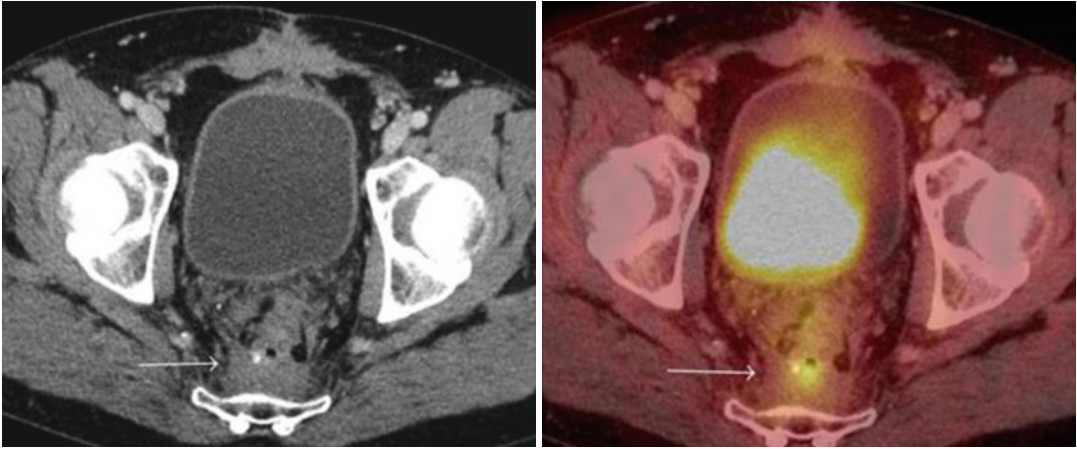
Doubtful recurrence of rectal cancer seen in CT image (*left*) (*arrow*). Confirmation of malignancy in PET-CT image (*right*) (*arrow*)
